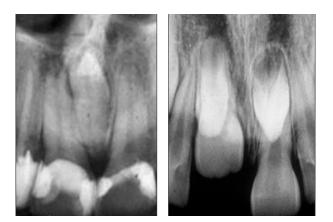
and 24B. Periapical radiographs of single inverted (A) and multiple mesiodens (B).
